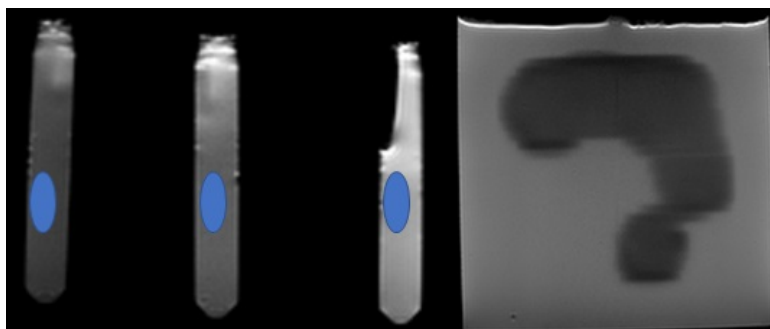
Acquired MRI images corresponding to cuboid A. Left: calibration vials, right: slice at approximately 0.75 cm depth in cuboid A.
